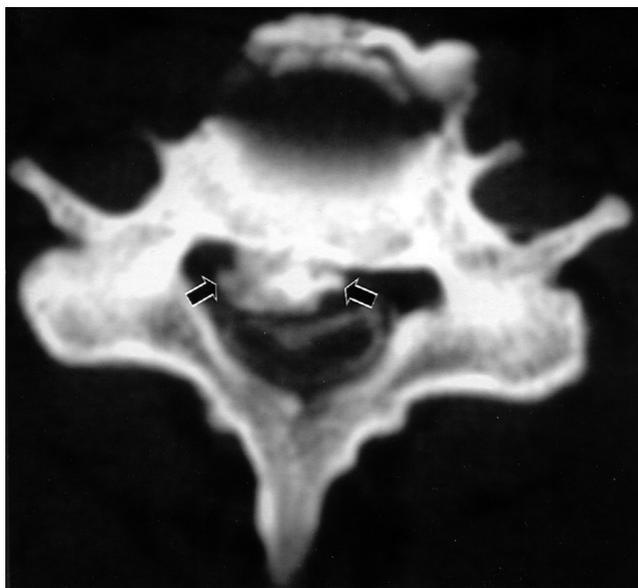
Computed tomographic myelography: epidural blocking of contrast medium reduced to a narrow strip at C5, due to OPLLS (arrows).
